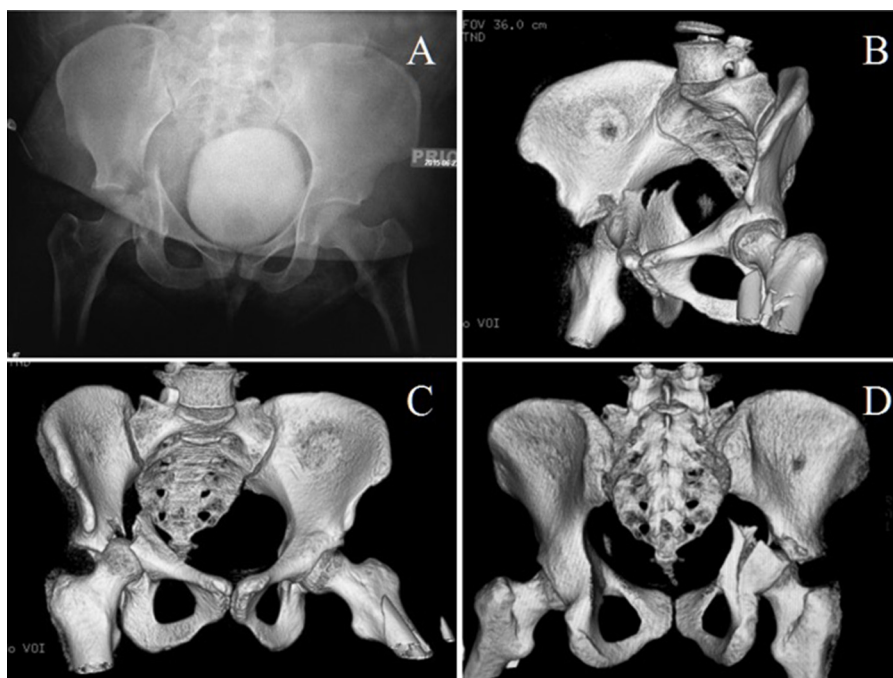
Pelvic radiograph AP view (A) of the right transverse posterior wall acetabular fracture and 3D CT reconstructions of the right acetabular fracture (B–D).
